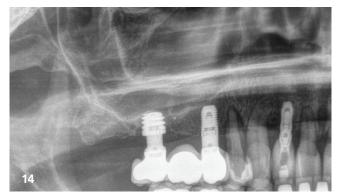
Radiograph with the definitive prosthesis in place, showing complete graft consolidation and evident bone gain beyond the implant apex. – Fig. 14: Radiograph at ten-year follow-up, demonstrating the long-term stability of the treatment, with sustained bone height gain, particularly noticeable in the distal region.
